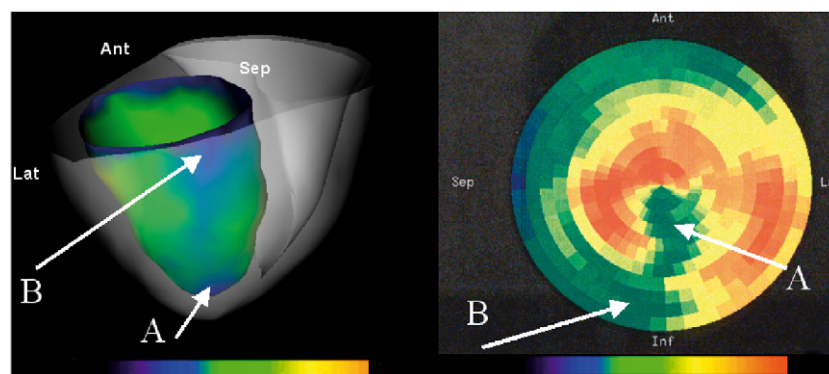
Left: 3-D representation of the FDG PET uptake values on the biventricular heart model for patient P2. Right: corresponding bull's eye representation (Siemens software) with values estimated at mid-wall location. The low LV FDG uptake areas (arrows A, B) can be seen clearly in darker colors in the figures.
